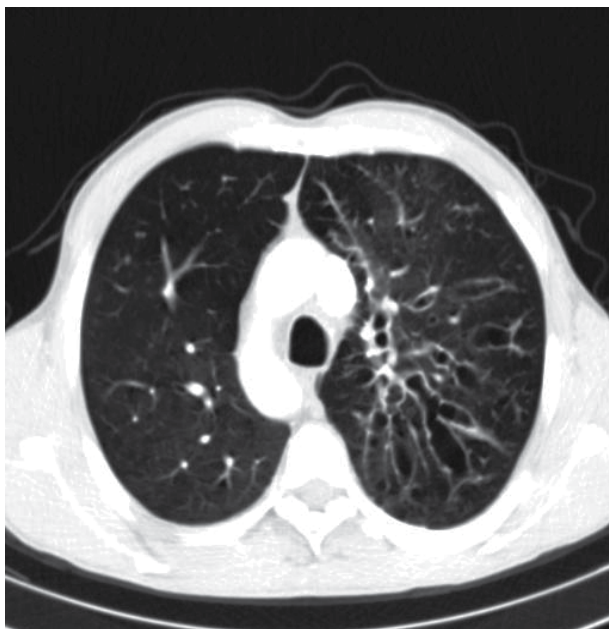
Computed tomography scan showing the classic image of Kartagener's syndrome characterized by dextrocardia and cylindrical bronchiectasis in the right upper lobe (patient's left side).
